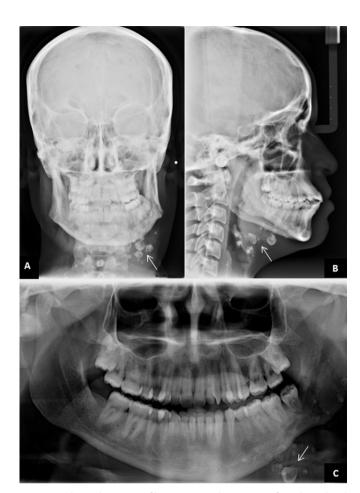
Radiographic images of hemangioma. The presence of circular and oval calcified structures were observed (arrows). (A) posteroranterior cephalometric. (B) Lateral cephalometric. (C) Panoramic radiograph.
